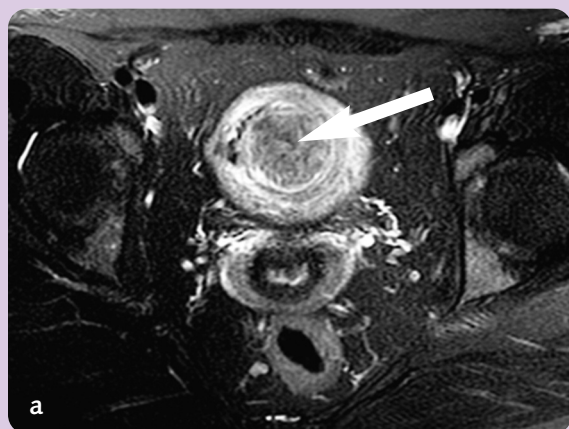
(a) Axial T2-weighted fat suppressed image of a 42-year-old female with a 35.2mm fibroid *pre-embolization*. (b) Axial T2-weighted fat suppressed image of the same patient *after* embolization. The fibroid measures 13.4 mm.
